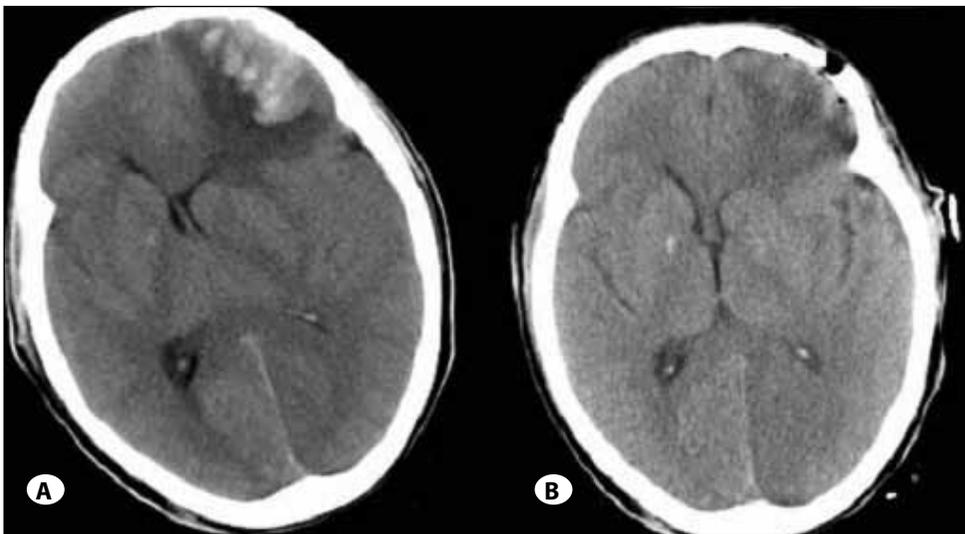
Pre- and postoperative computed tomography(CT) scan of type IV strategy. (A) Preoperative CT scan showing contusion of left frontal lobe. (B) The contusion was resected on postoperative CT.
